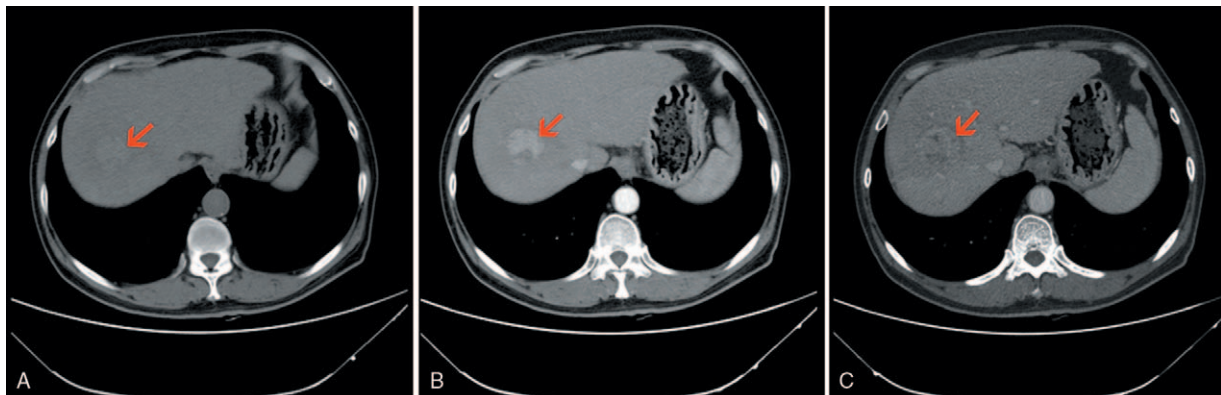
Abdominal CT showed a hypodense tumor (red arrow) in the right liver: (A) plain scan phase; (B) arterial phase; and (C) portal venous phase. CT=computed tomography.
